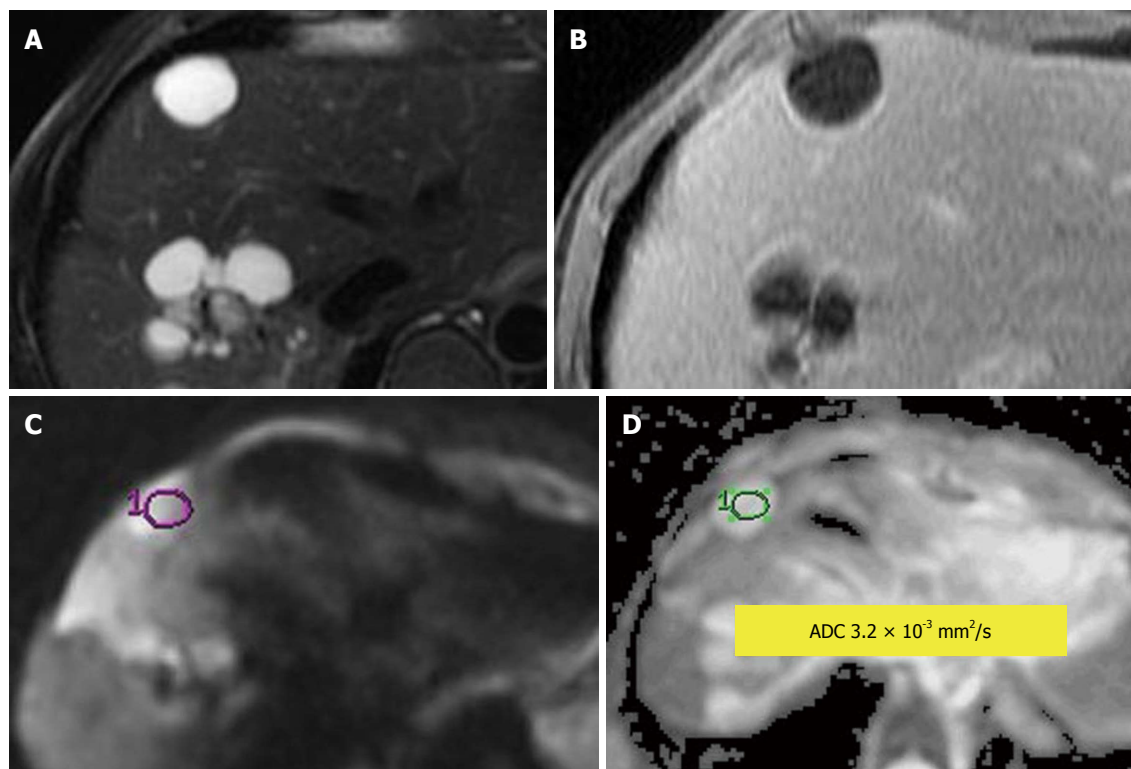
Simple hepatic cyst. A: Fat-suppressed T2-weighted (T2W) Fast Spin-Echo; B: Enhanced T1-weighted gradient recalled-echo; C: Diffusion-weighted image; D: Apparent diffusion coefficient (ADC) map. A T2W hyperintense non-enhancing lesion consistent with a simple cyst with $ADC = 3.2 \times 10^{-3} \text{ mm}^2/\text{s}$. No impeded diffusion is visible.
